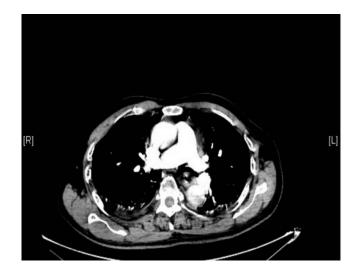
Contrast-enhanced CT of the chest showed no obvious filling defect in the pulmonary artery.
